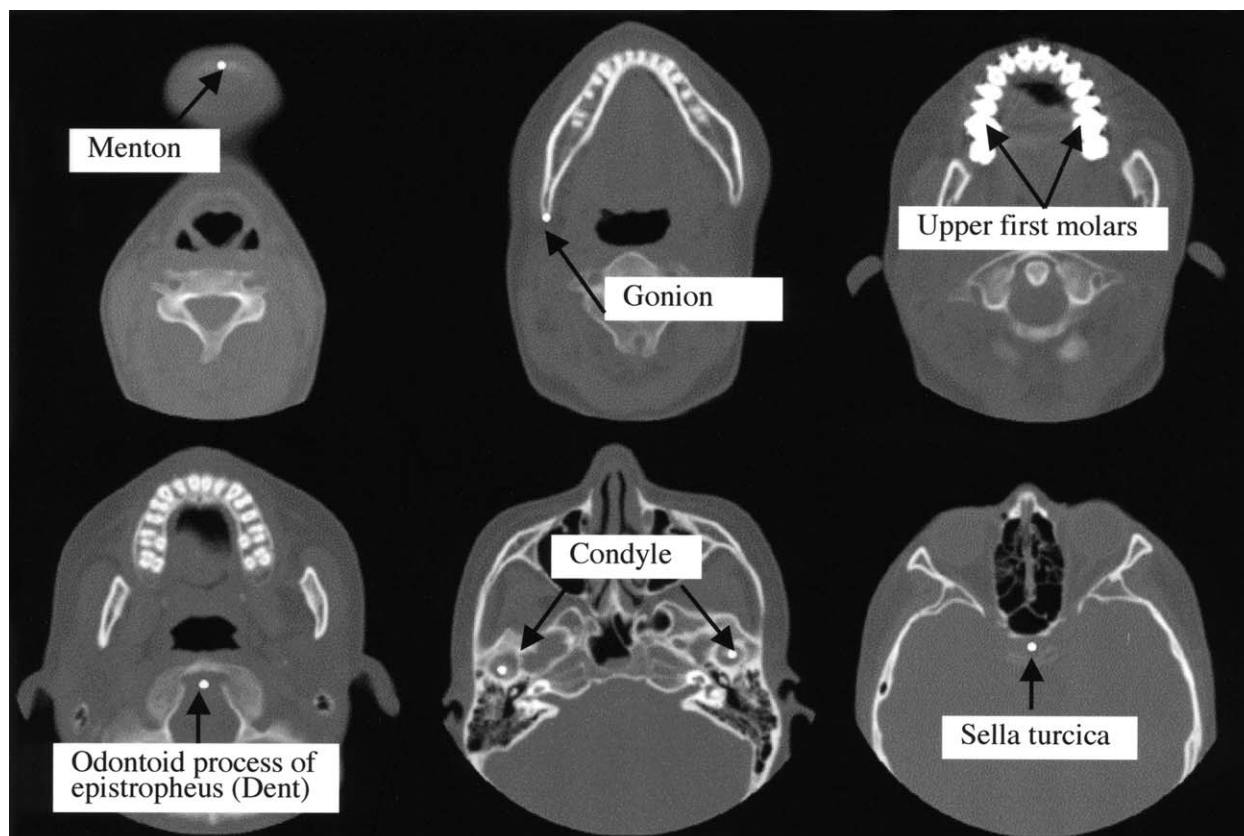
Selected anatomical landmarks as defined in the axial slice CT images.
